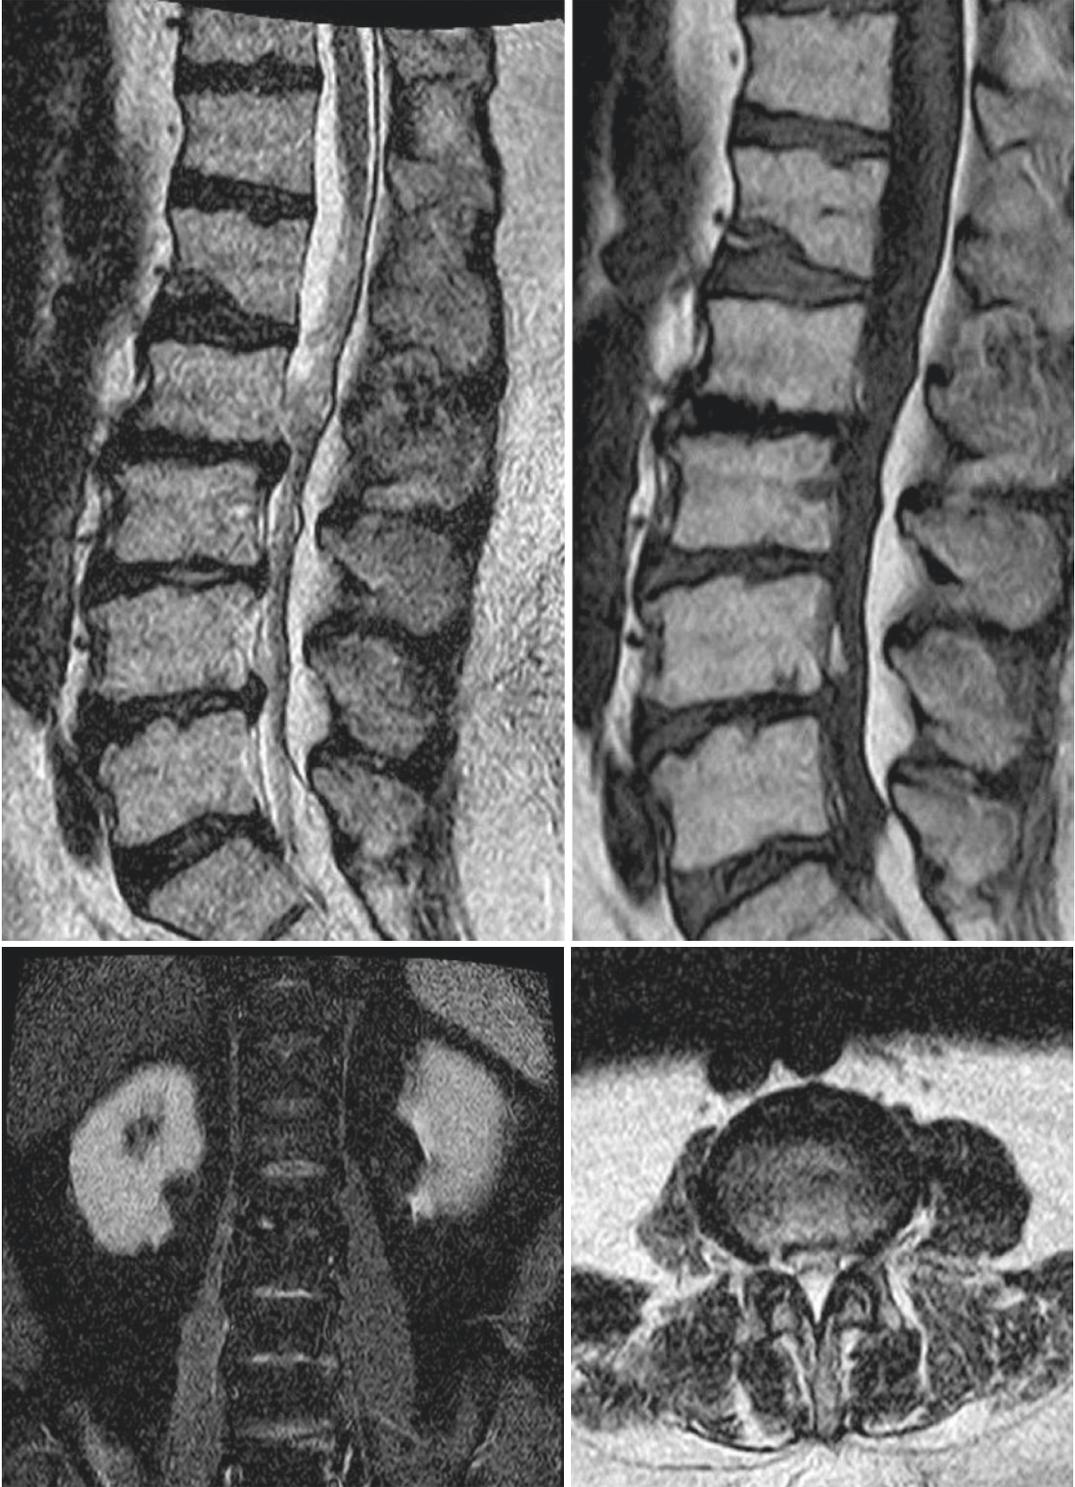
Magnetic resonance imaging lumbar spine at the same time
